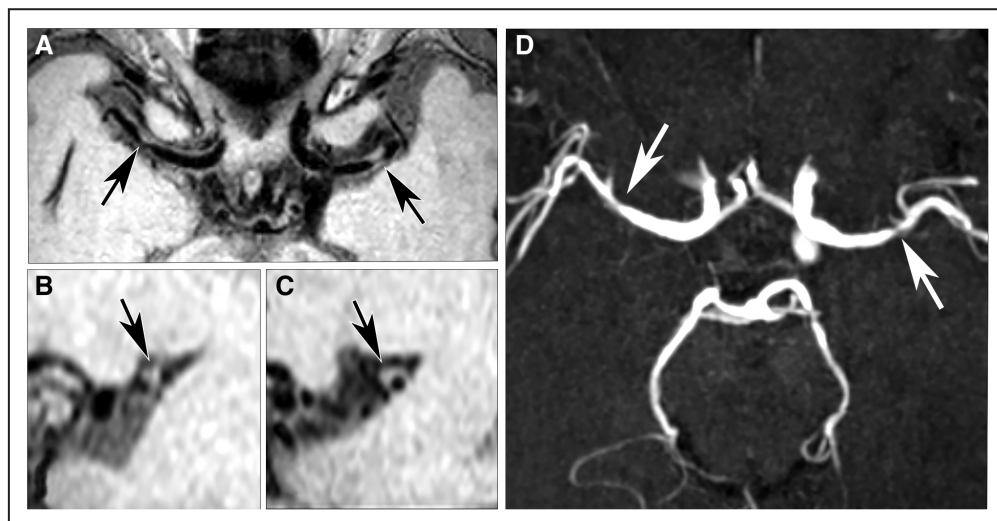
A 78-year-old female patient presented with an acute left transient ischemic attack. A, Bilateral focal vessel wall lesions were observed in the middle cerebral arteries on the transverse T1-weighted volumetric isotropically reconstructed turbo spin echo acquisition image (arrows in A). Sagittal image reconstructions of the (B) right middle cerebral artery (MCA) lesion and (C) left MCA lesion showing that both lesions are eccentric. D, Transverse time-of-flight magnetic resonance angiography shows a corresponding symptomatic left MCA stenosis and an asymptomatic irregular right MCA (arrows in D).
